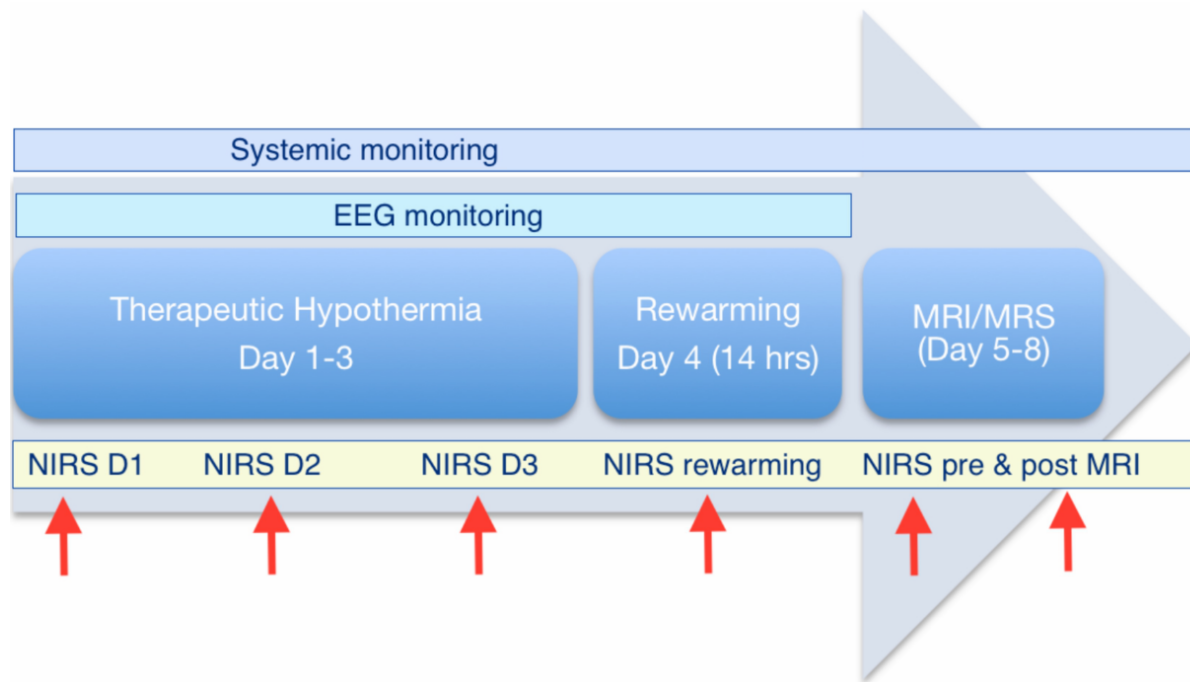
Typical time line of treatment and monitoring from birth to day 7 of life. Cooling starts as soon as possible after birth for 72 hours. NIRS starts as early as possible once parental consent is obtained. MR scan (MRI and ^1H MRS) occurs for 1 hour between days 4 and 15 of life.
